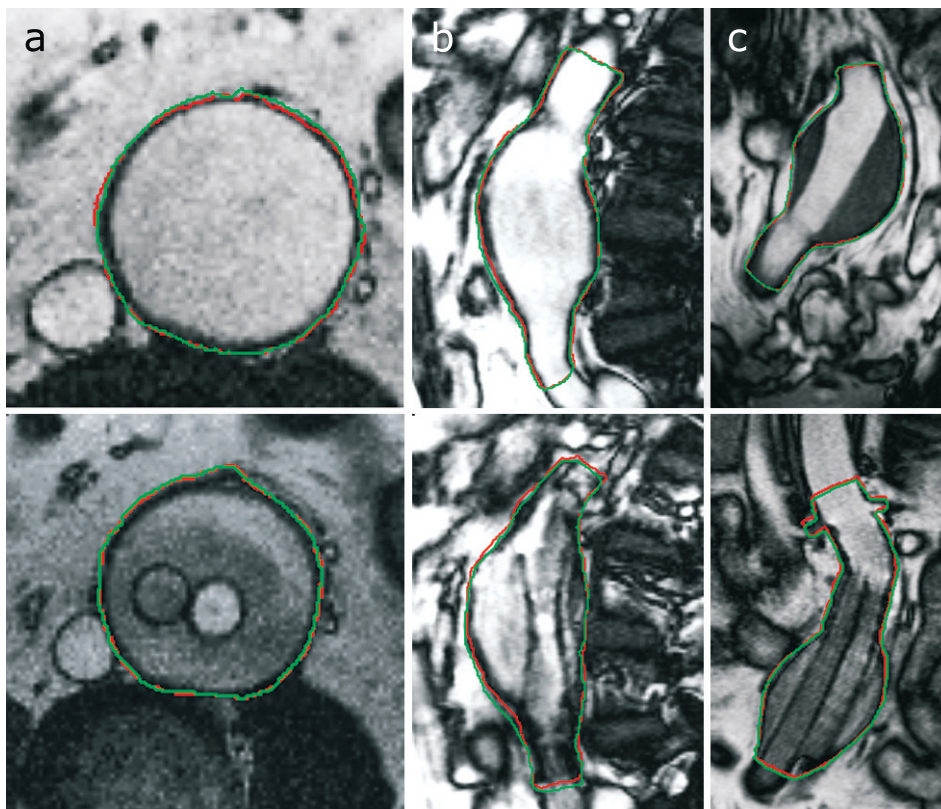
(A) Transverse, (B) sagittal, and (C) coronal sections from a cine MRI study of an aortic aneurysm at peak-systole before (above) and after (below) EVAR. The superimposed contours at peak systole (green) and end-diastole (red) show patterns of translation.
